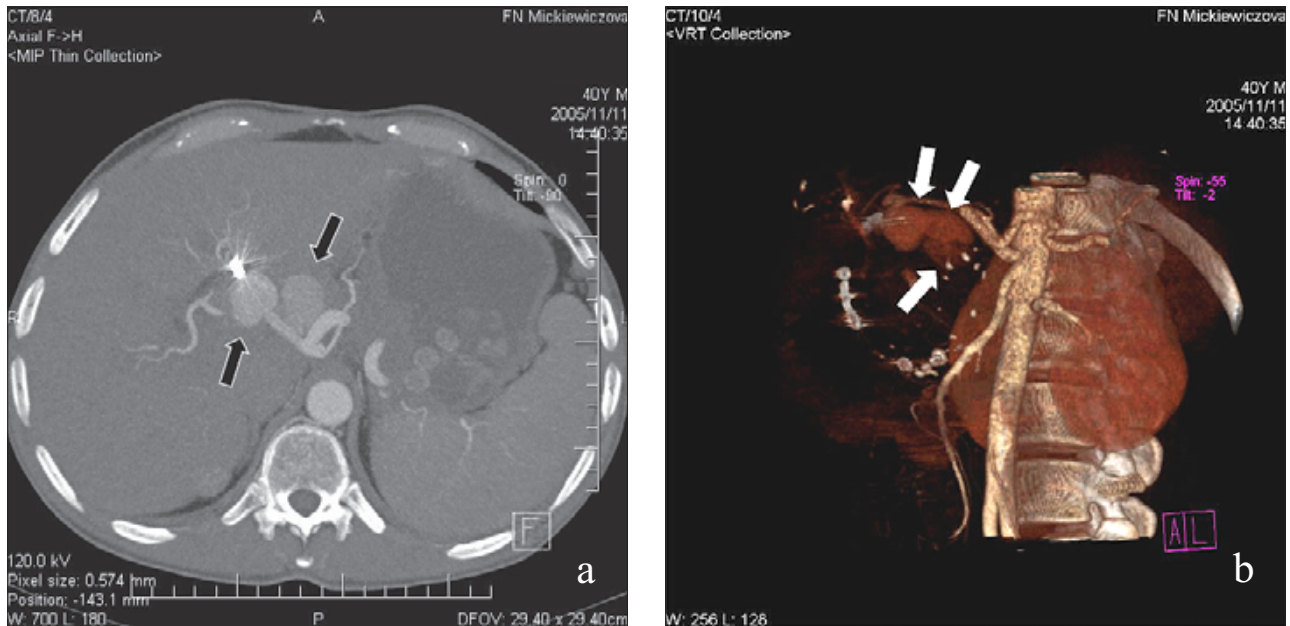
a) CT angiography shows two from the three chamber pseudoaneurysm of the right hepatic artery (arrows). b) The 3D reconstructed celiac CT angiography demonstrates that the pseudoaneurysm of the right hepatic artery is built by three chambers (arrows).
